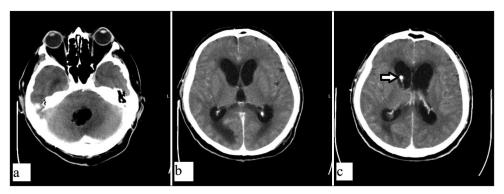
Follow-up enhanced CT scans revealed (a) total removal of the abscess and (b) consequent triventricular hydrocephalus. External ventricular drainage (c, arrow) is properly placed in the rightsided frontal horn of the ventricle.
